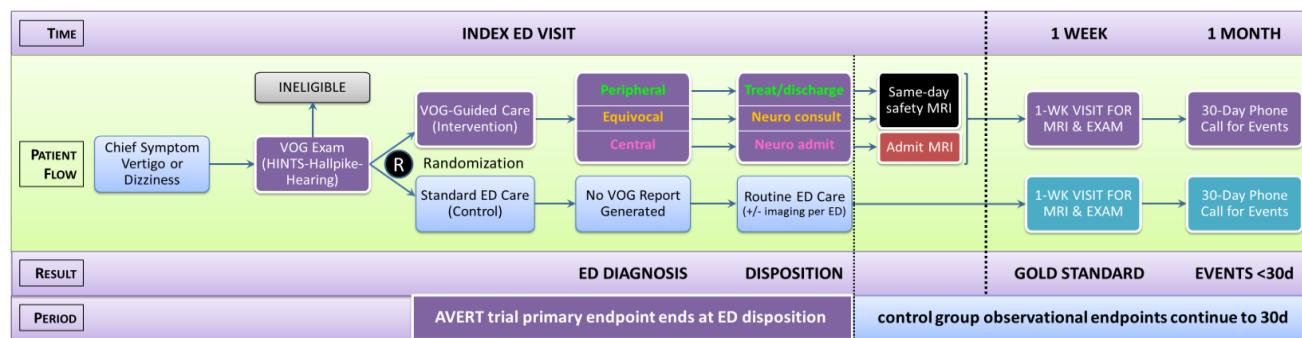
AVERT Trial patient flow. R = randomization. The VOG-guided rapid triage (VRT) algorithm selects a predetermined care pathway using decision rules. If the VRT algorithm diagnosis is peripheral, the patient will be slated for treat and discharge from the ED, followed by same-day safety MRI. ED providers may go ‘off protocol’ and insist on admission for safety, and may choose to consult another provider (e.g., ENT physician, vestibular physical therapist) for treatment of BPPV or vestibular neuritis if study treatment procedures appear ineffective. If the VOG diagnosis is equivocal, a neurology consultation is required, with subsequent management determined by ED provider and consultant(s) working together. The requirement for neurology consultation may be waived in cases where doing so could not feasibly be accomplished within a reasonable time frame; in such a case, the ED provider would determine subsequent management without the assistance of a neurologist. If the VOG diagnosis is central, the research team will request that the ED provider order a neurology consultation, neuroimaging (MRI), and admit the patient for further evaluation and testing, even if the ED provider believes the patient has a peripheral cause; a note to this effect will be placed in the patient’s medical chart as part of the research record. The ED provider will make the final decision whether to admit the patient. If the ED provider elects to discharge the patient, this would be documented as a protocol deviation. Funds permitting, we will also obtain 6-month phone follow-up.
